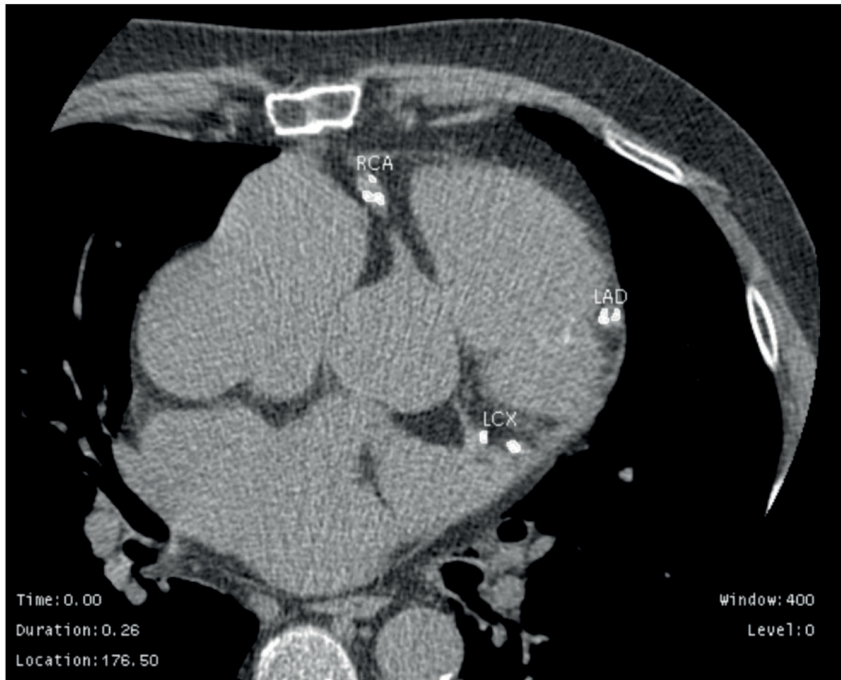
Coronary artery calcification as measured by coronary CT.
